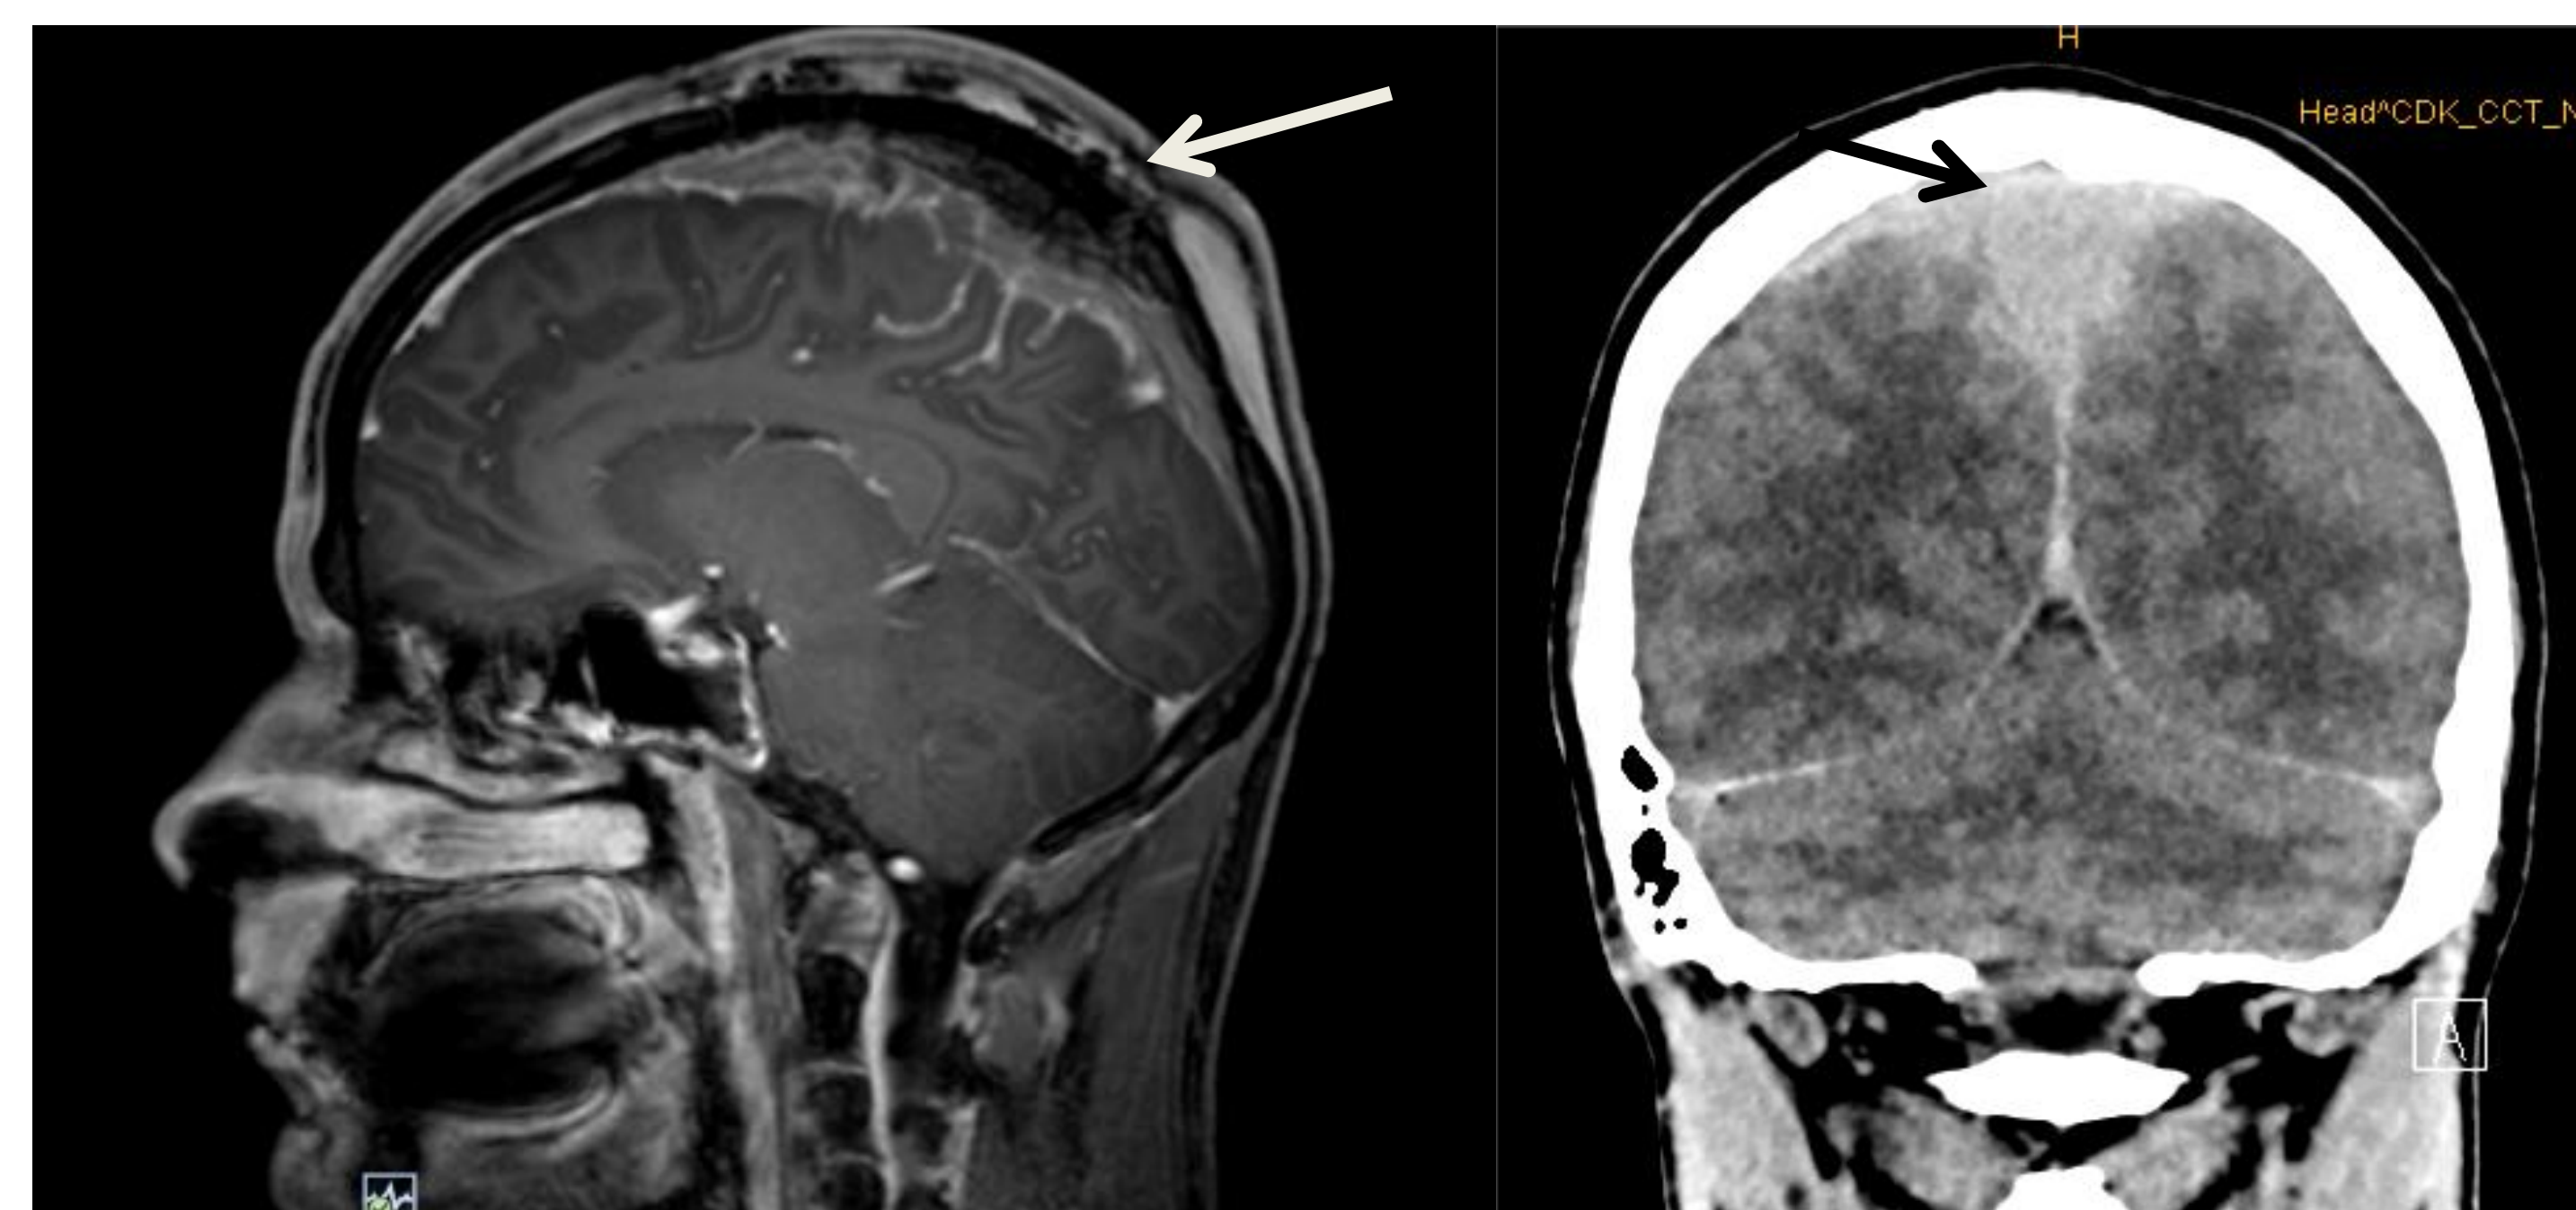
MRI-scan showing localization of intracranial bleeding tumour
